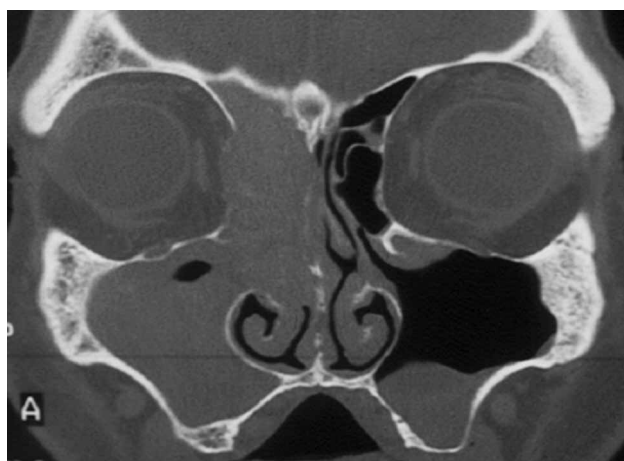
Computed tomographic scan. Coronal view showing a bone lysis and orbital expansion of the right maxillary sinus cavity.
